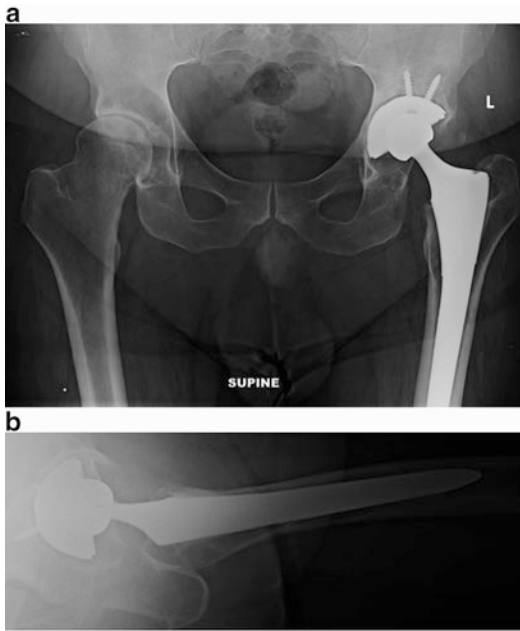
Anteroposterior pelvis (a) and cross-table lateral (b) radiographs demonstrating a circumferential radiolucency around the acetabular component and radiolucent irregularities at the proximal femur suggestive of chronic infection. This patient was diagnosed with a periprosthetic infection based on an elevated erythrocyte sedimentation rate, C-reactive protein, and positive hip aspiration for *Propionibacterium acnes*
